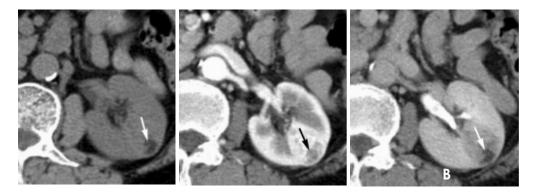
Patient aged 57 years, showed at the native CT examination a small nodular formation hipodense, that after the administration of contrast substance was noted as bigger, representing both peripheral contrast enhanced CT and central zone of necrosis
